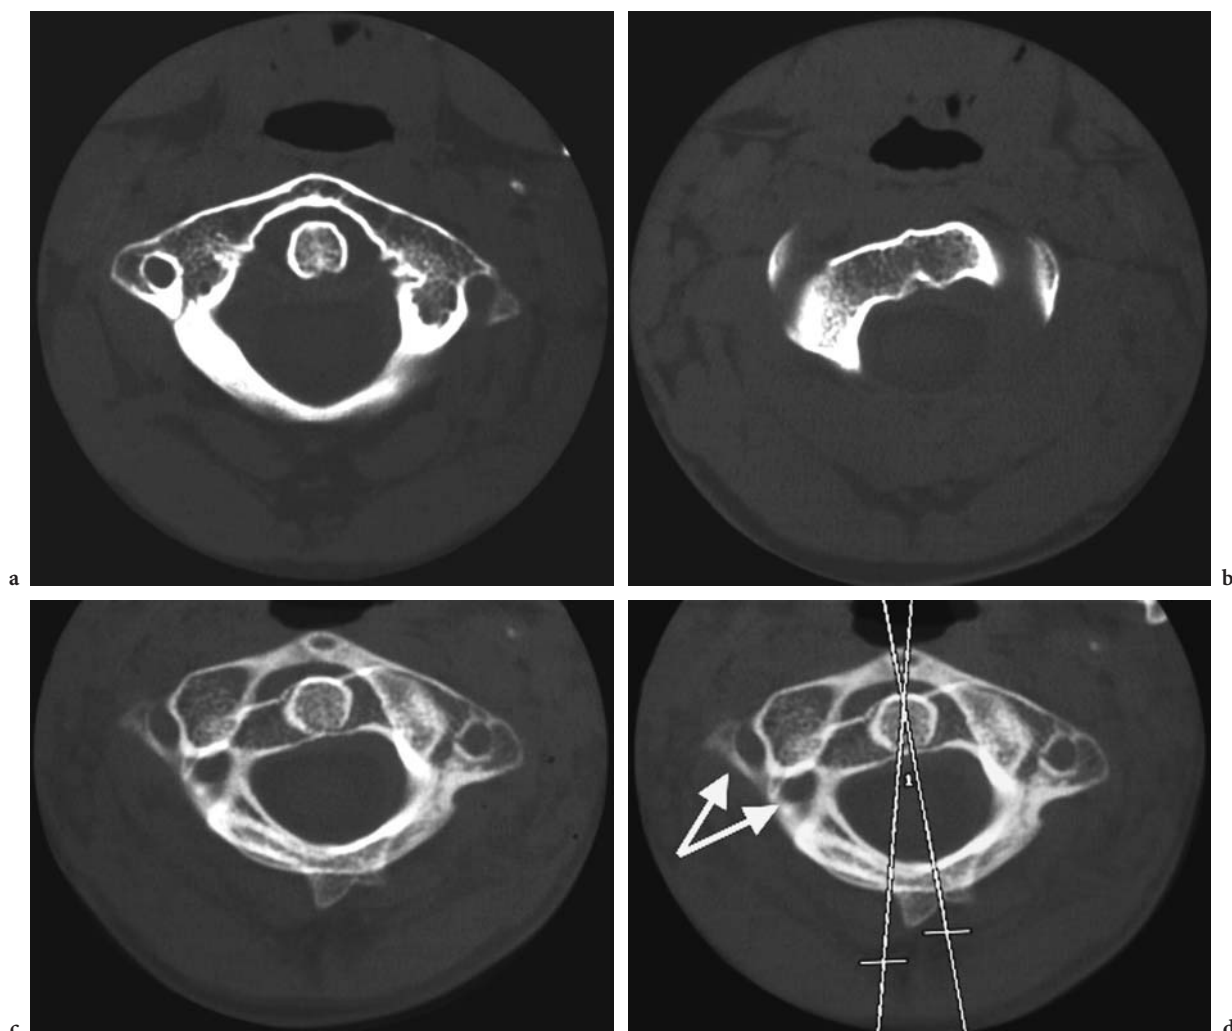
Rotatory atlanto-axial dislocation. a Axial CT image through the atlanto-dental articulation. b Axial CT image through the rotated vertebral body of C2 and the lateral masses of the atlas. c Thick MIP axial projection of C1 and C2 vertebral bodies. d 14° Rotation of axis. Note the posterior projection of the C2 vertebral foramen (arrows)
